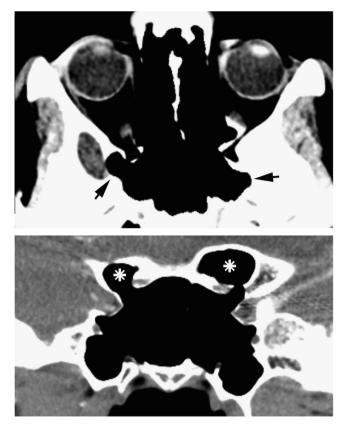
Axial computed tomography (top). Sphenoid "bubble sign", occurring with expansion of the sphenoid sinus with chronic intracranial hypotension. The sphenoid sinus is seen to extend far lateral to the posterior orbit (arrows). Coronal computed tomography (bottom). Aeration of the anterior clinoids occurring with chronic intracranial hypotension. The enlarged sphenoid sinus has extended into the anterior clinoids (°). Sphenoid bubbling clinoid aeration are indicative of advanced intracranial hypotension related skull remodeling.
